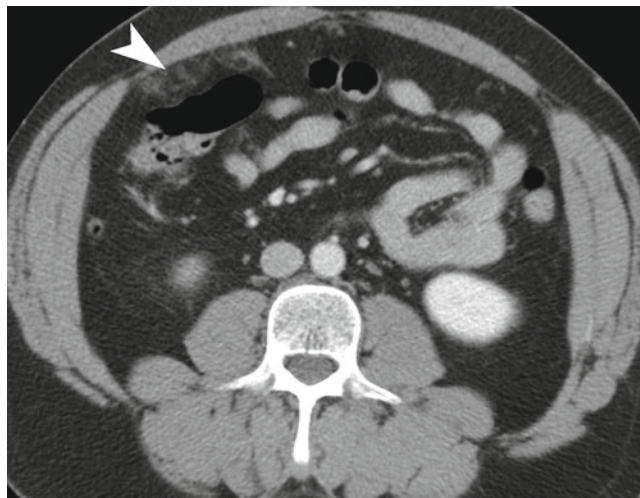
Omental contusion. Contrast-enhanced CT demonstrates fat stranding in omental fat (*arrowhead*) due to traumatic omental contusion
